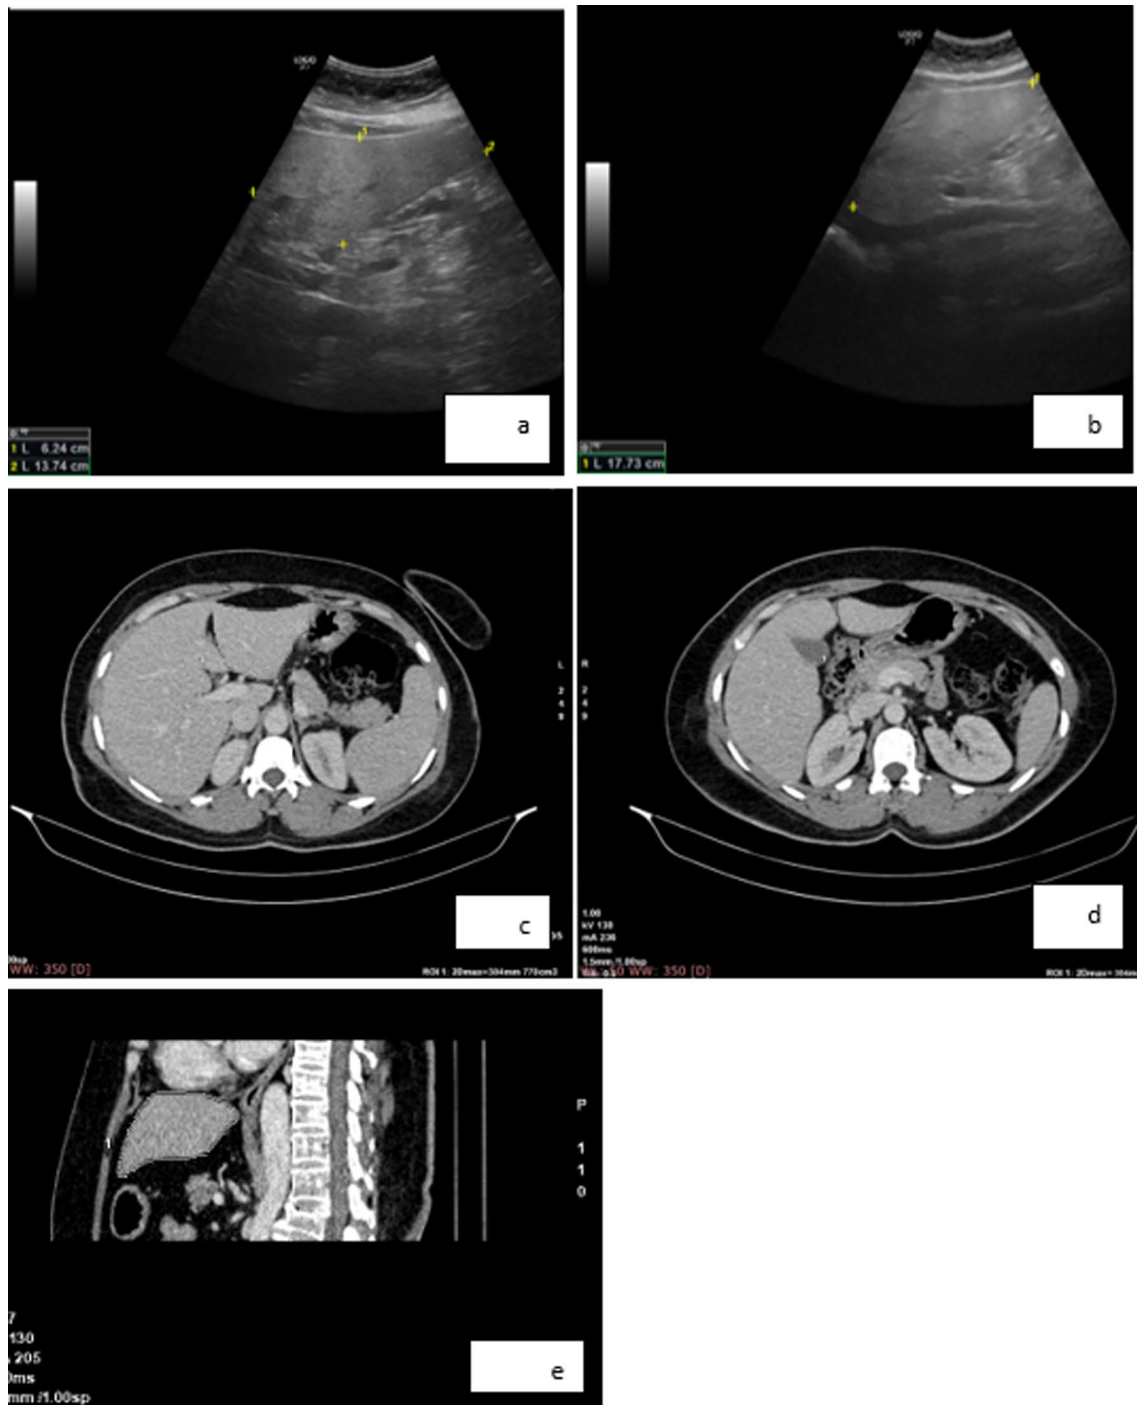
a–e US and CT images for 28 years old female with a BMI = 51. a and b US images measuring the height, length, and width with the estimated LHL volume by ultrasound = 781.8 cm³. c and d axial CECT images and e sagittal CECT image estimating the LHL volume = 770 cm³
